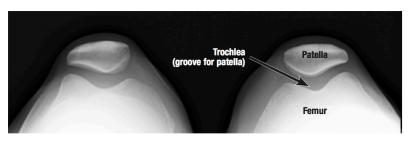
Radiograph of the patellofemoral joint with the knee in slight flexion. The lateral aspect of the trochlear groove is normally about 1 cm higher than the medial.
